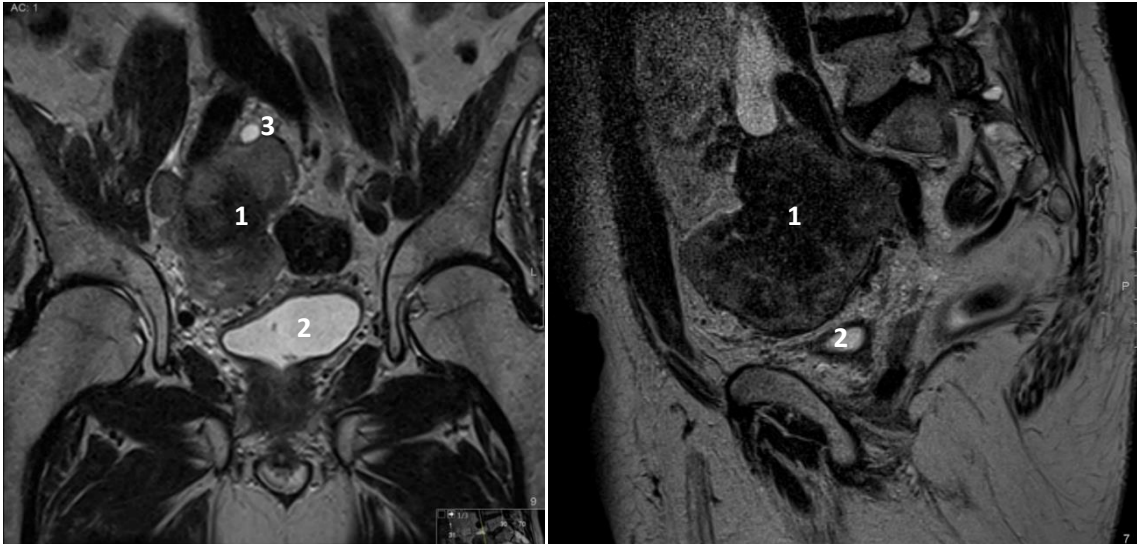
Coronal oblique (A) and sagittal (B) sections of preoperative abdominal and pelvic MRI (T2 sequence) where the tumor (1), bladder (2) and right ureter (3) are shown.
